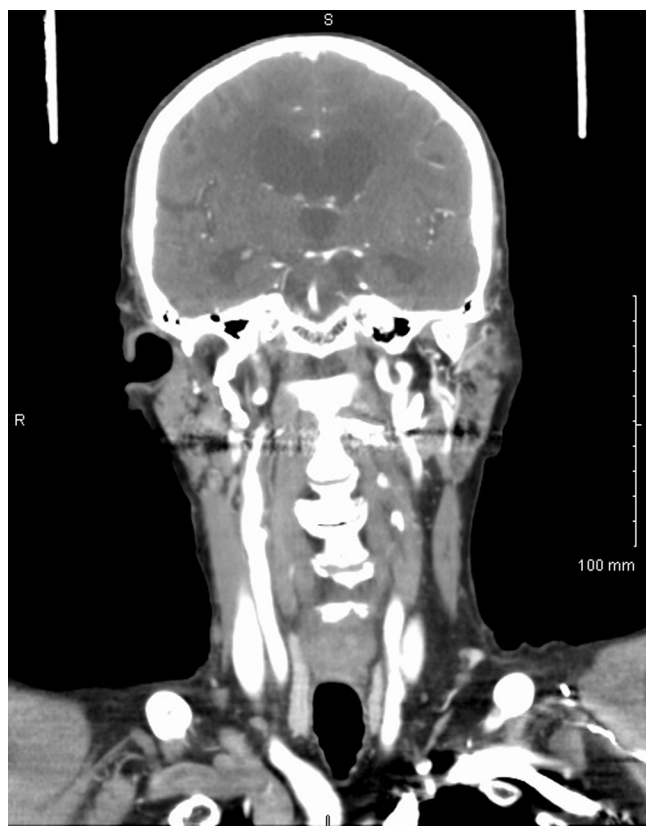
A sagittal CT scan of a patient with an elongated styloid hyoid complex (We would like to acknowledge Dr. Roy Holliday from Mount Sinai Health System for providing these images).
